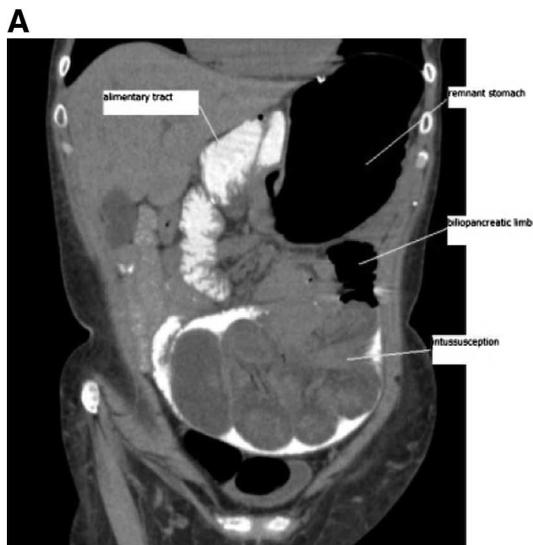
Coronal CT with remnant stomach, biliopancreatic limb, alimentary tract, and intussusception identified.
